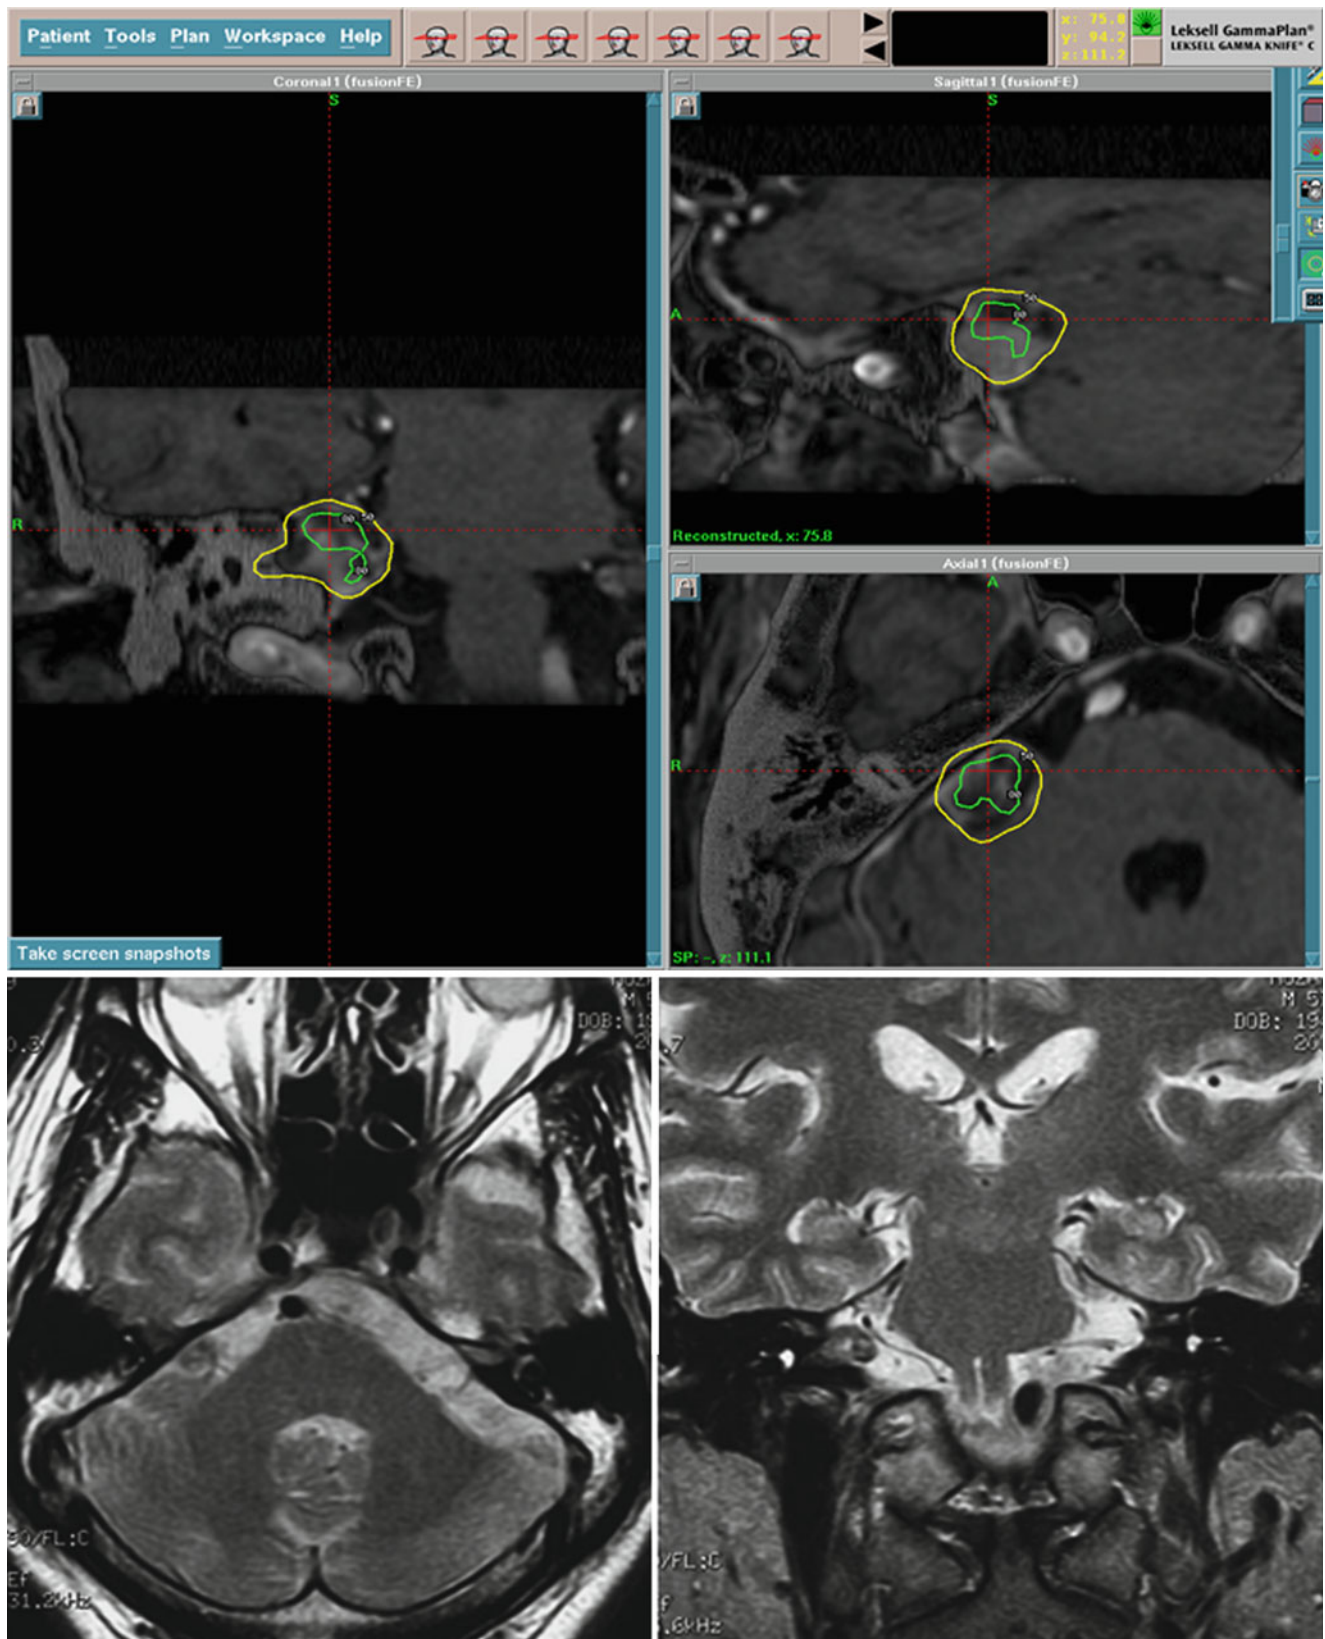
GKS dose planning for a Koos stage III vestibular schwannoma (upper) and follow-up magnetic resonance imaging 2 years thereafter (lower). The treatment was based on fused gadolinium-enhanced T1-weighted and “bone window” CT images. The tumor was conformally
